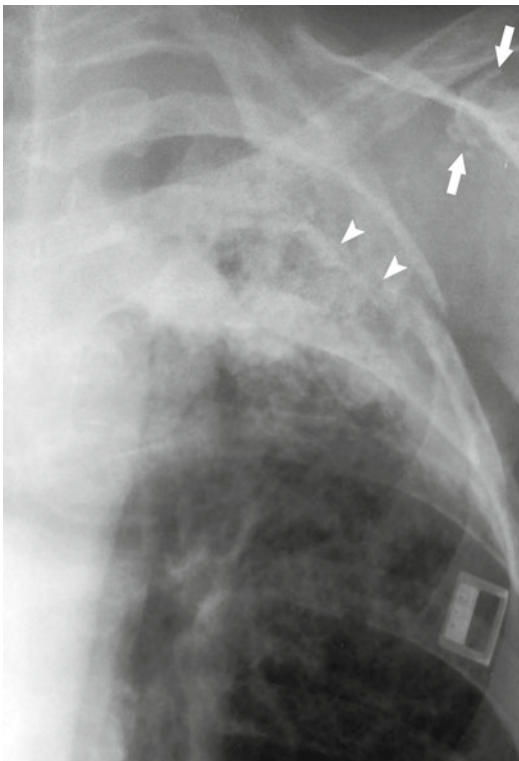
Radiation osteonecrosis. Coned-down PA chest radiograph shows left upper lobe radiation fibrosis. The coracoid process of the scapula (*arrows*) and left fourth rib (*arrowheads*) are fragmented, and the other bones in the radiation field are sclerotic
